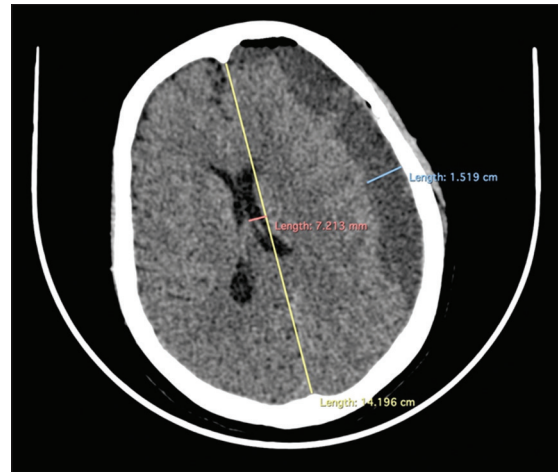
Computed tomography scan after burr hole and drainage. Chronic subdural hematoma thickness was 1.5 cm with a 7.2-mm midline shift
